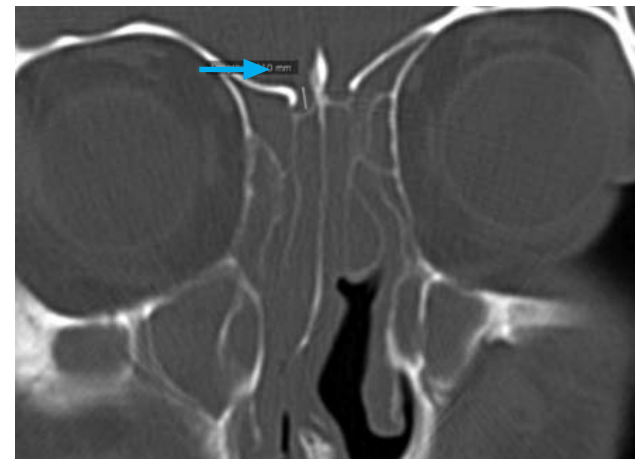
Coronal view of CT PNS: Depth of olfactory fossa measures about 2.8 mm falling under Kero's type I classification.
